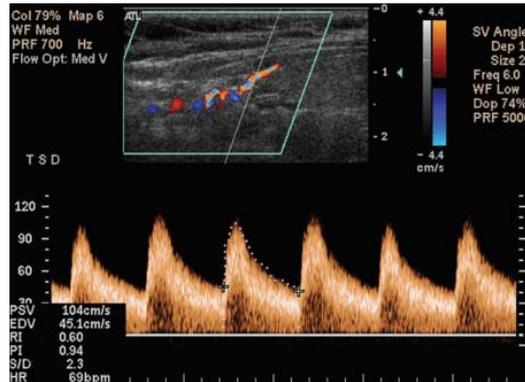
Duplex-colour Doppler of the superior thyroid artery with the probe positioned in the oblique sagittal Flow Parameter Measured the Peak Systolic Velocity (PSV) and (RI).
